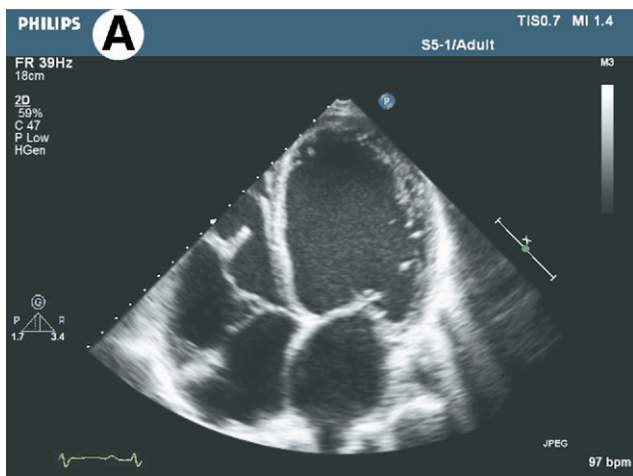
(A) Standard 2D transthoracic echocardiographic image of the left ventricle. (B) This image appears flat because the scanning lines are in a plane. The frame rates of 2D echo are faster than those of 3D. (Color version of figure is available online at <http://www.semthorcardiovasc.org>.)
